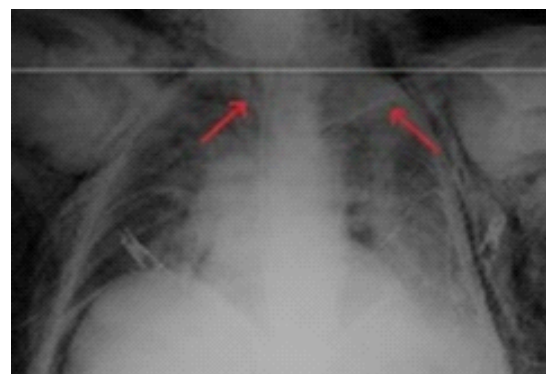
The bedside chest X-ray (CXR) is showing that bilateral small-diameter pleural drainage catheters (red arrows) and widespread subcutaneous emphysema.
